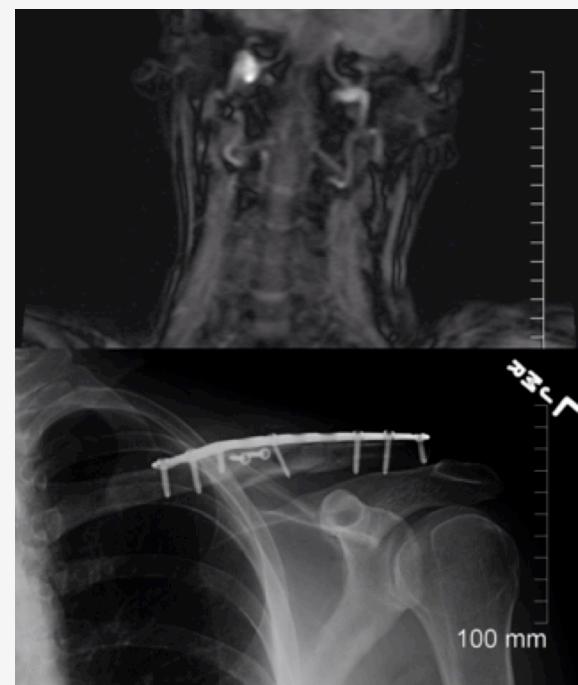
(above) Top: Computed tomography revealing a mildly displaced unilateral left lateral mass fracture of the atlas Bottom: Plain film of surgically repaired left highly comminuted clavicle.
